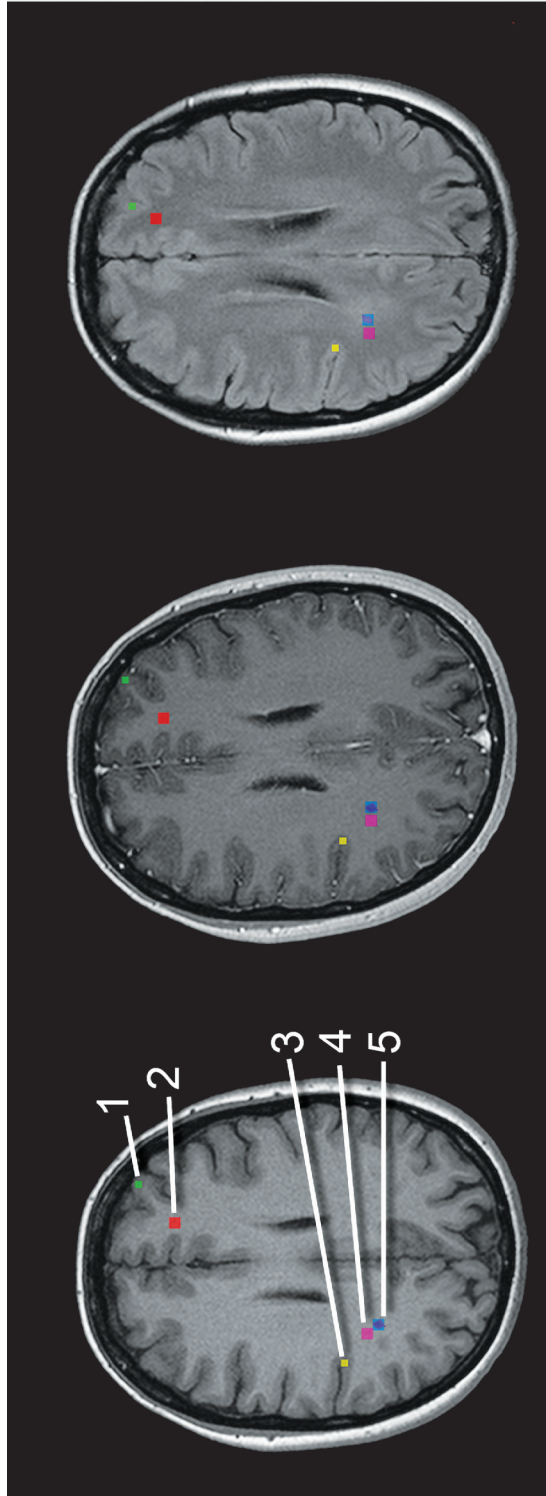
Brain images from the corona radiata, with ROIs indicated on the images. Left, T1w MPR image; centre, T1w MPR image with contrast agent; right, FLAIR image. Different ROIs are represented by numbers and colours: 1) green, cortex apart from lesions (grey matter); 2) red, white matter; 3) yellow, cortex near lesion (normal-appearing grey matter) 4) pink, normal-appearing white matter and 5) blue, MS plaque (10x10 ROI) and violet, hand-drawn MS plaque.
